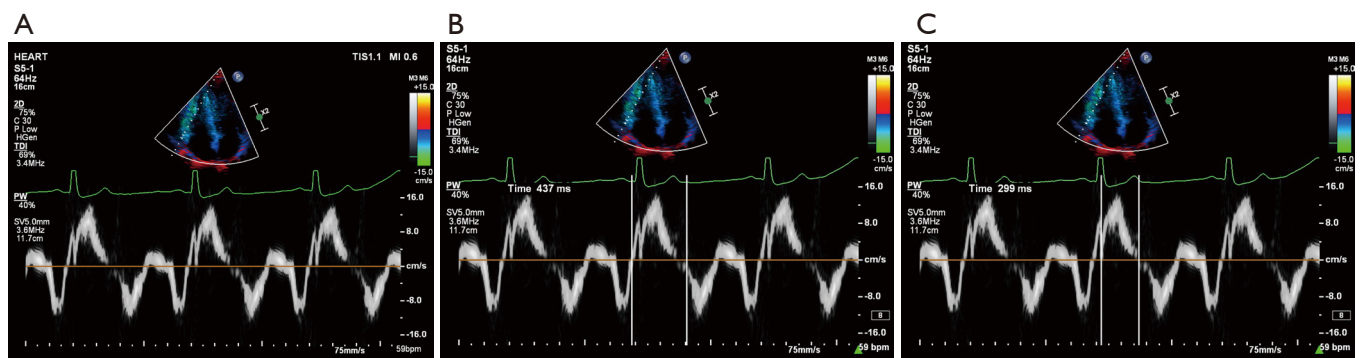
Measurement of Tei index. (A) Tricuspid annulus tissue Doppler spectrum. (B) Tricuspid valve opening to closure time (a). (C) Right ventricular ejection time.
